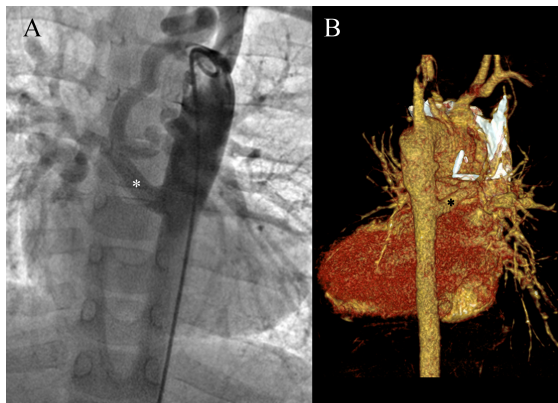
A: Invasive angiogram- aortic angiogram showing large aorto-pulmonary collateral (*) in a patient with Tetralogy of Fallot; B: Computed Tomography- volume rendered three-dimensional image showing a large aorto-pulmonary collateral (*) in the same patient.
